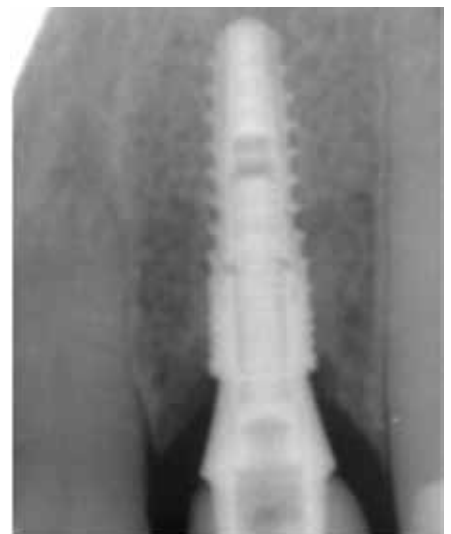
Radiograph of Case Loaded 18 months.
